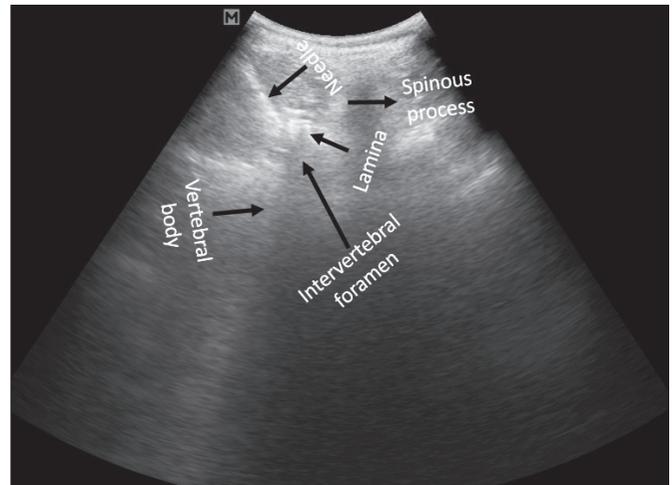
Final sonographic view in axial approach. Intervertebral disc is determined, which would be between the border of vertebral body and lamina in this view. The epidural needle parallel to the peripheral catheter is pushed forward toward intervertebral foramen under guide of sonography in axial approach and is stopped at the edge of the foramen. In this picture, the root is distinguishable, which is not always recognizable.
